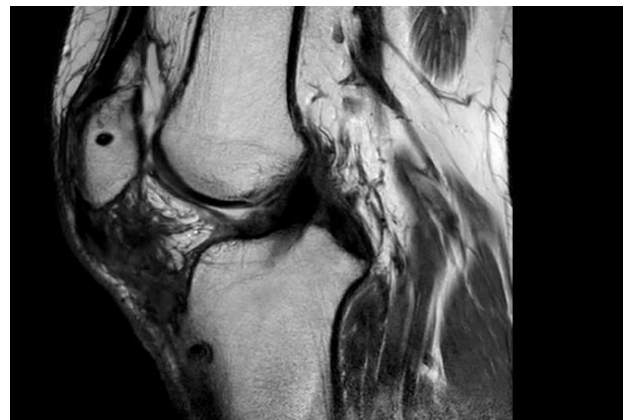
Six month follow up MRI sagittal view showing patellar and tibial tunnels for attaching semitendinosus autograft with intact graft.
